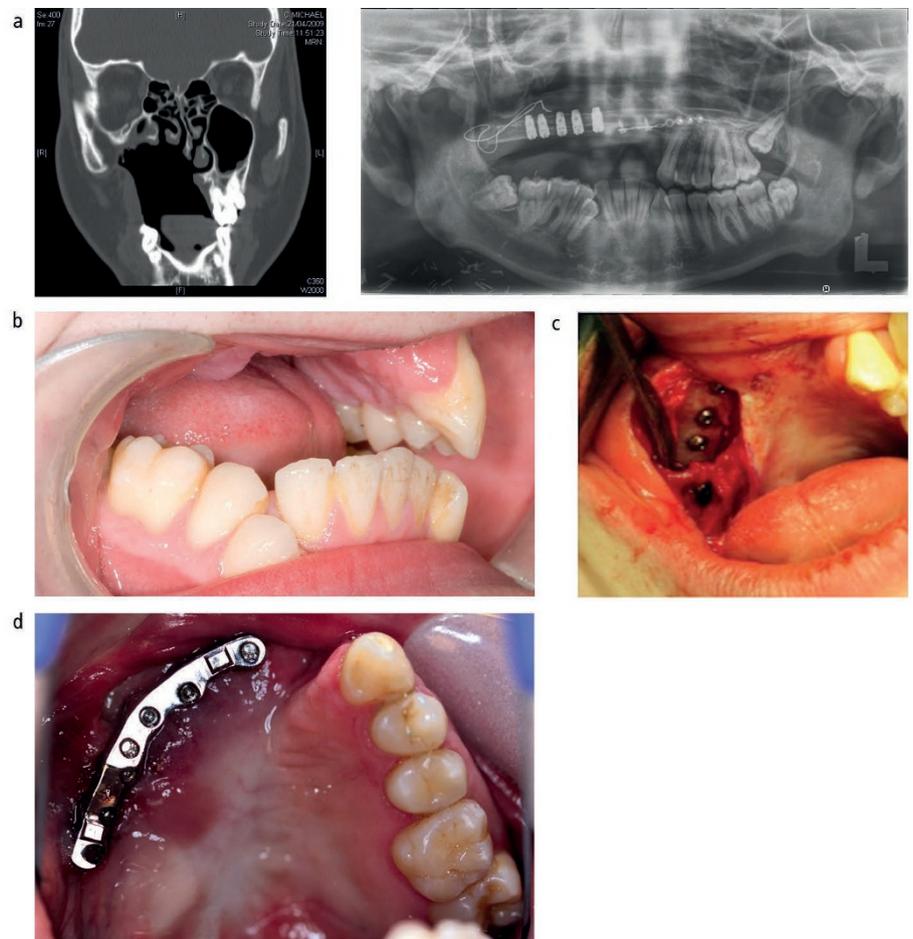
Radiographs of a young patient following a hemi-maxillectomy. (a) Free flap inserted at completion of growth; (b) Photograph taken immediately following implant placement in the same patient; note the challenging soft tissue anatomy; (c) Photograph taken of implant-supported CAD/CAM milled titanium beam; (d) Following placement of the scapula free flap, a 3D lithographic model was printed from the patient's CT scan replicating the bony anatomy. Implant planning and surgical stent construction was undertaken on the lithographic model and the CT images used in implant planning software. Following implant placement and exposure, an implant retained pressure plate was used to create more favourable soft tissue contour. This is a clear plate whereby the master model has been relieved in specified areas, such that when it is inserted it exerts pressure on the tissues and causes pressure necrosis to create a buccal sulcus
